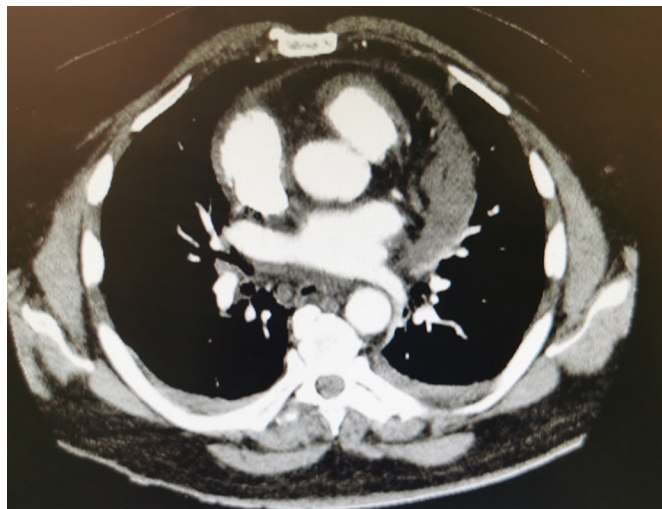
A slice from a CT pulmonary angiogram demonstrating the pericardial effusion.
